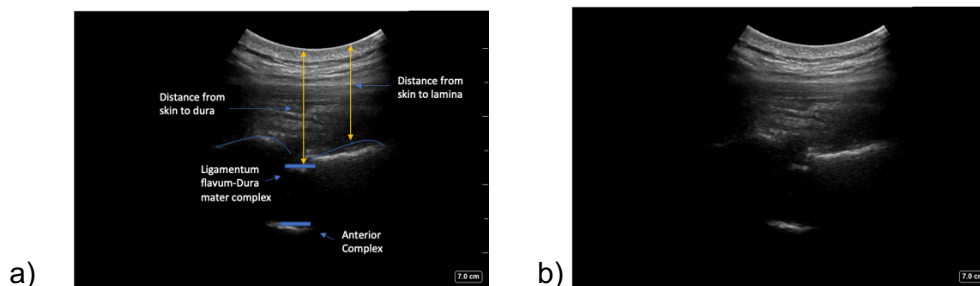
Posterior medial sagittal oblique view demonstrating “sawtooth” view of thoracic laminae. Thin hyperechoic lines demonstrate ligamentum flavum-dura mater complex and anterior complexes. Measurements from skin to lamina and dura, respectively, demonstrated in a) annotated image and b) original image. Images obtained using curvilinear ultrasound probe (8-3MHz).
